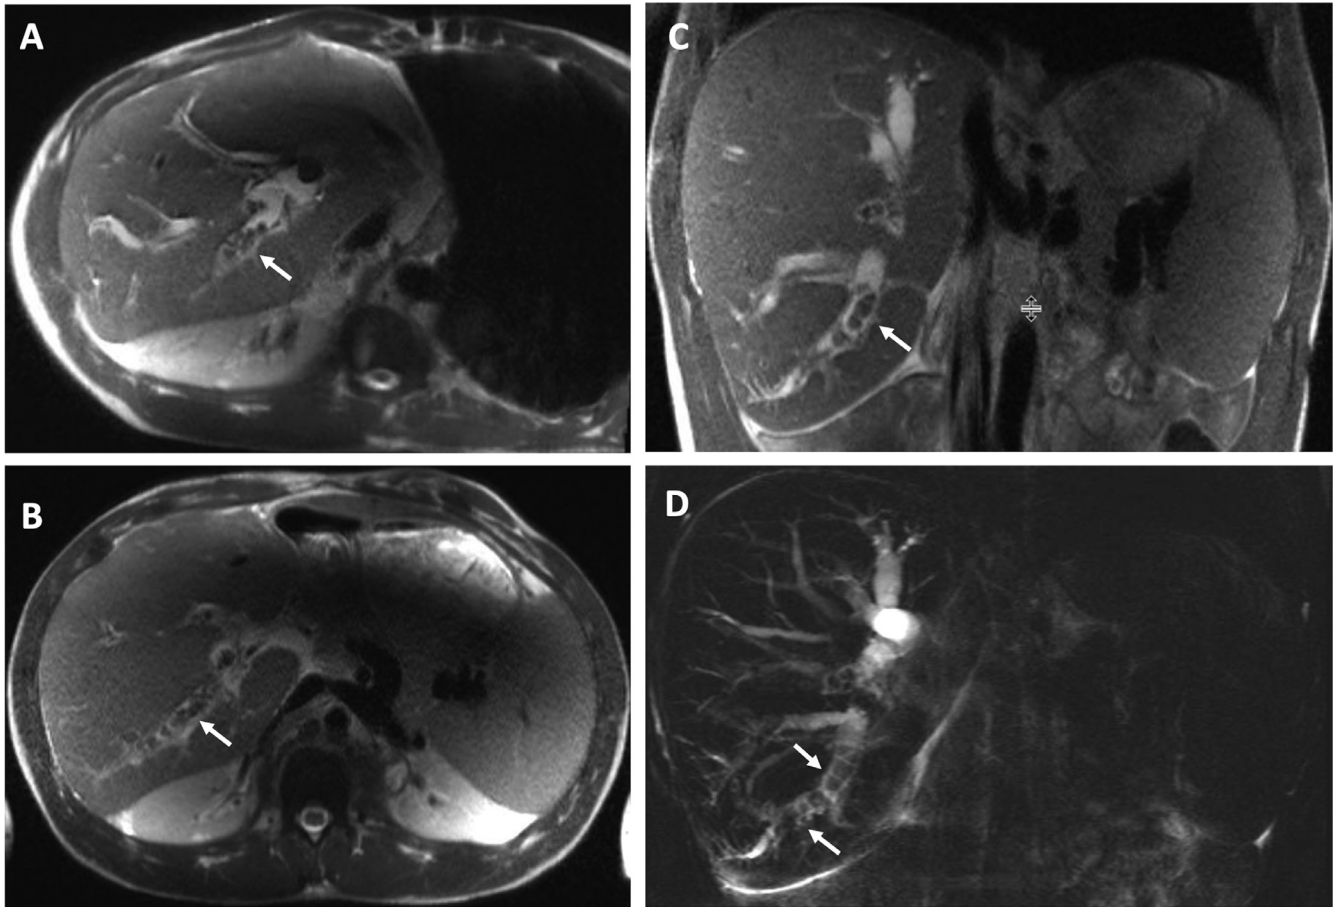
MRI of abdomen 1 day after presentation. Axial (A and B), coronal (C), and MRCP (D) views. Liver transplant is noted in the right upper quadrant. There is marked intrahepatic biliary dilatation, with multiple intraluminal gallstones (white arrows) including a 1-cm stone at the right main duct and near complete occlusion of the right posterior biliary duct.
